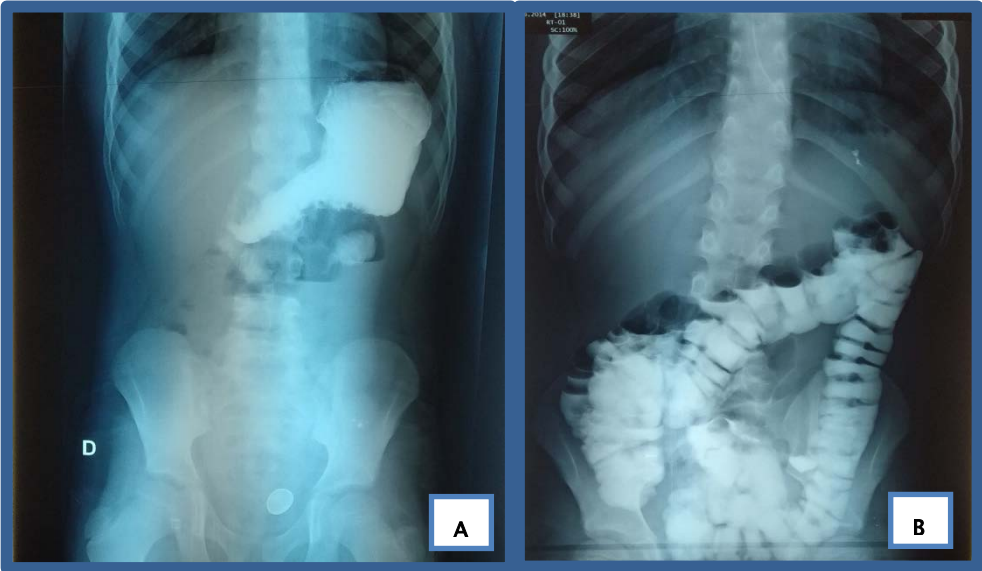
Abdominal Radiographs of a 13 years old male patient. A- AXR obtained 3 hours after Gastrographin administration showing contrast in the stomach. B- AXR obtained 12 hours after Gastrographin administration showing the presence of the contrast in the large bowel
